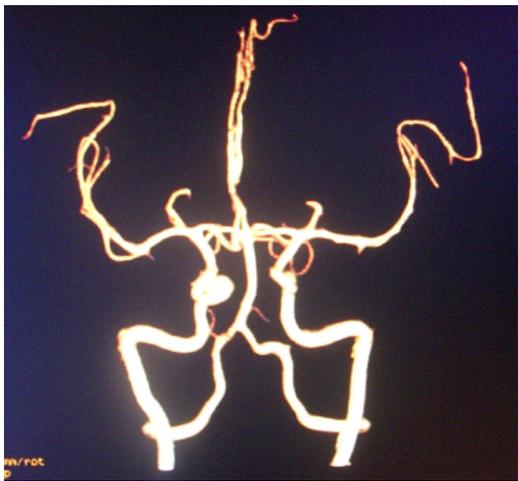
Cerebral CT Angiogram shows left MCA vasospasm.
